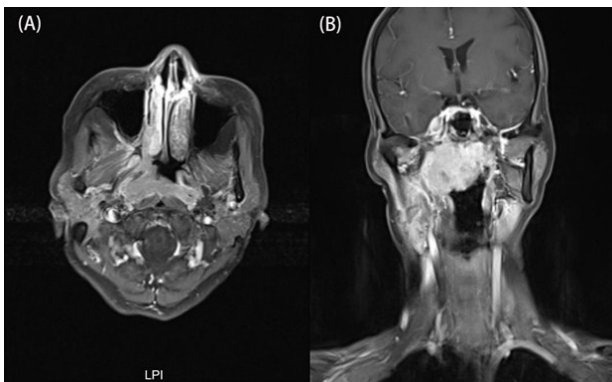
MR image before treatment showed irregular thickening of the nasopharyngeal walls on both sides and the parietal wall, extending to the right maxillary sinus lateral wall, right orbital apex. (A):T1-weighted Axial MRI image. (B):T1-weighted coronal MRI image.
